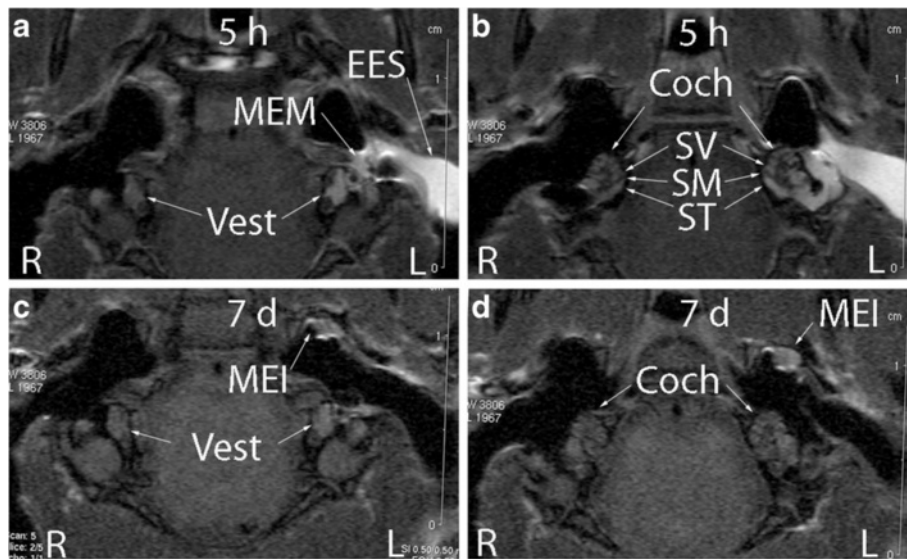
Gd-contrasted MRI showed that dynamic changes in the permeability of the biological barriers occurred in the middle ear mucosa, skin of the external ear canal, and the inner ear after exposure to 400 µg/ml AgNPs. Figures a and b are measured 5 h after exposure and figures c and d 7 d after exposure. Quantification data was shown in Figure 3. Coch: cochlea; MEI: middle ear infiltration; MEM: middle ear mucosa; SM: scala media; ST: scala tympani; SV: scala vestibuli; Vest: vestibulum.
